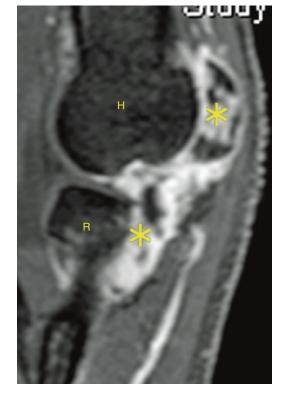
MRI T2 with STIR sequence of the elbow in a 35-year-old woman with inadequately treated RA showing effusion and synovitis (*asterisks*). *H* humerus, *R* radius
